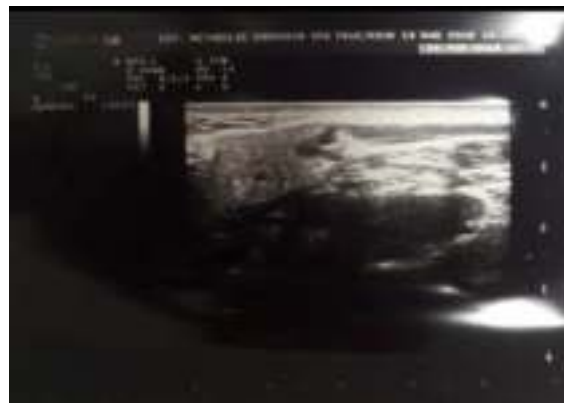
Neck ultrasound
